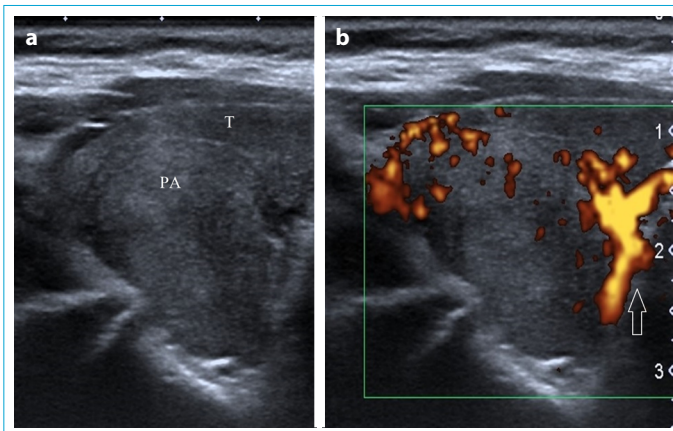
(a) Ultrasound image of a patient with complete intrathyroidal parathyroid adenoma (PA), surrounded with the right lobe of thyroid (T). (b) Color Doppler ultrasound of the same patient revealed a polar vessel (arrow) of adenoma.
